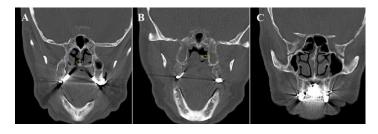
Computed tomography image A. Paranasal tomography shows the site of attachment of the polyp to the middle turbinate in the coronal section B. Choanal portion of the polyp. C. Aeration of the paranasal sinuses was normal
